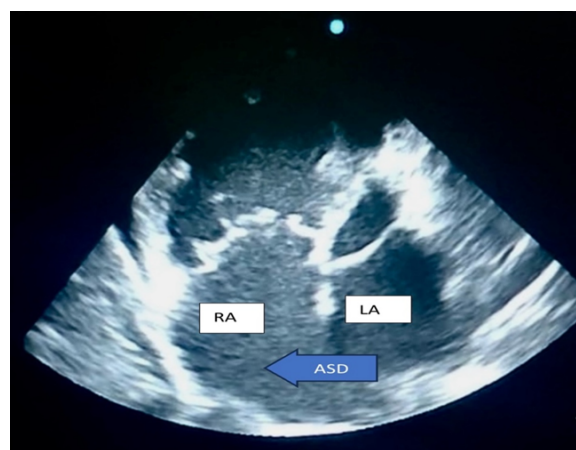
2D Echocardiography image showing right atrium (RA), left atrium (LA) and the atrial septal defect (ASD).
